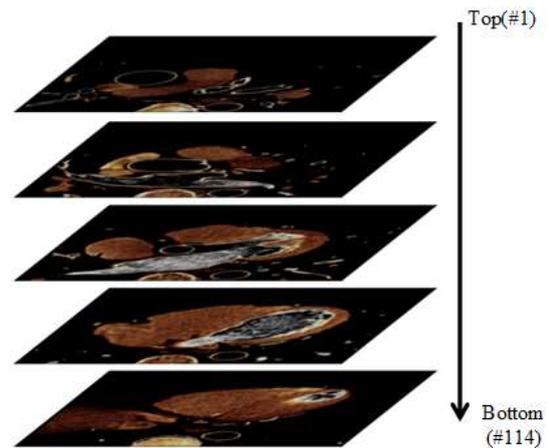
CT image of the heart.
